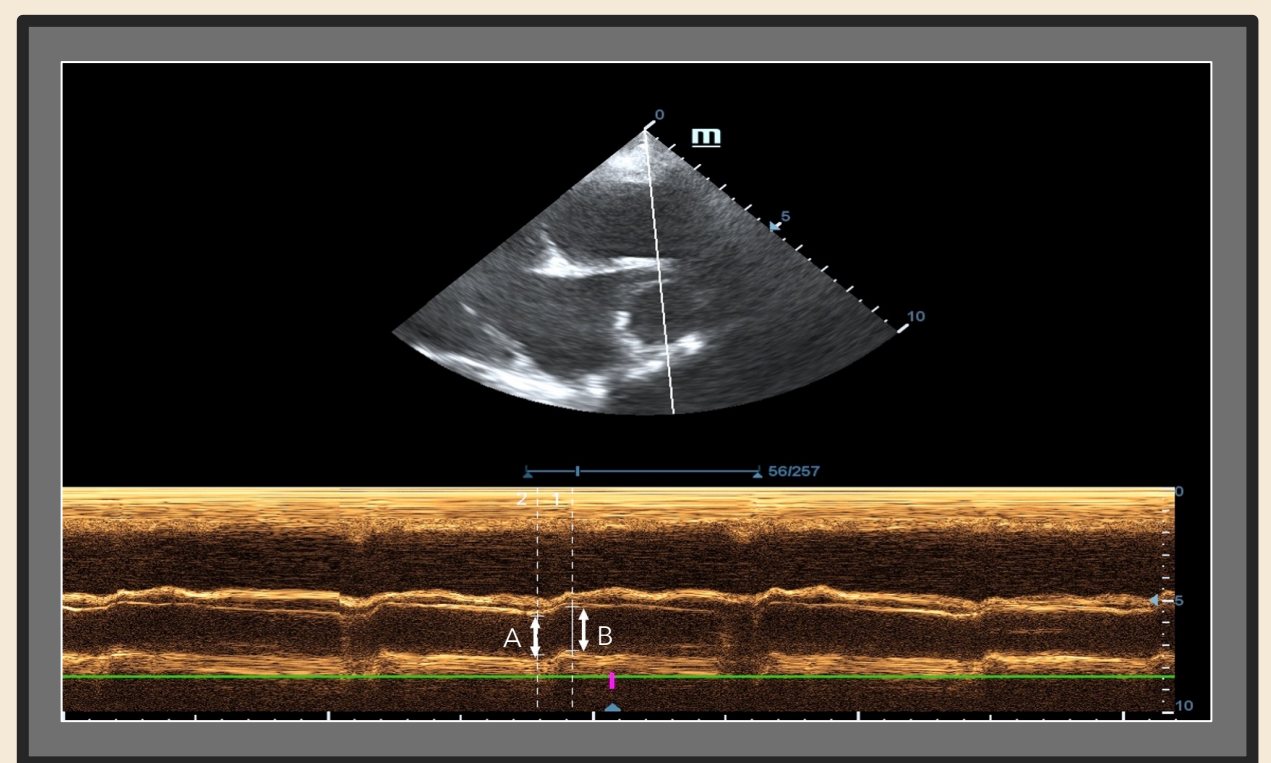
Measurement of the Right Pulmonary Artery Distensibility index (RPAD index) in a patient that presented severe pulmonary hypertension (20%). RPA measurement in systole (A). RPA measurement in diastole (B). Right parasternal position, four-chamber longitudinal section in M mode.
